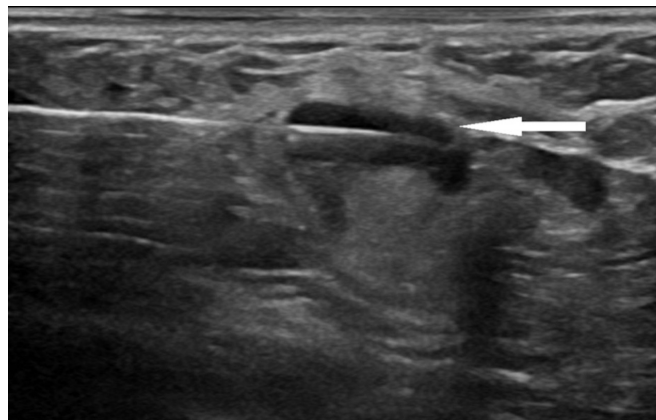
Ultrasound-guided core biopsy (arrow) with a 14-gauge needle and automated gun.
